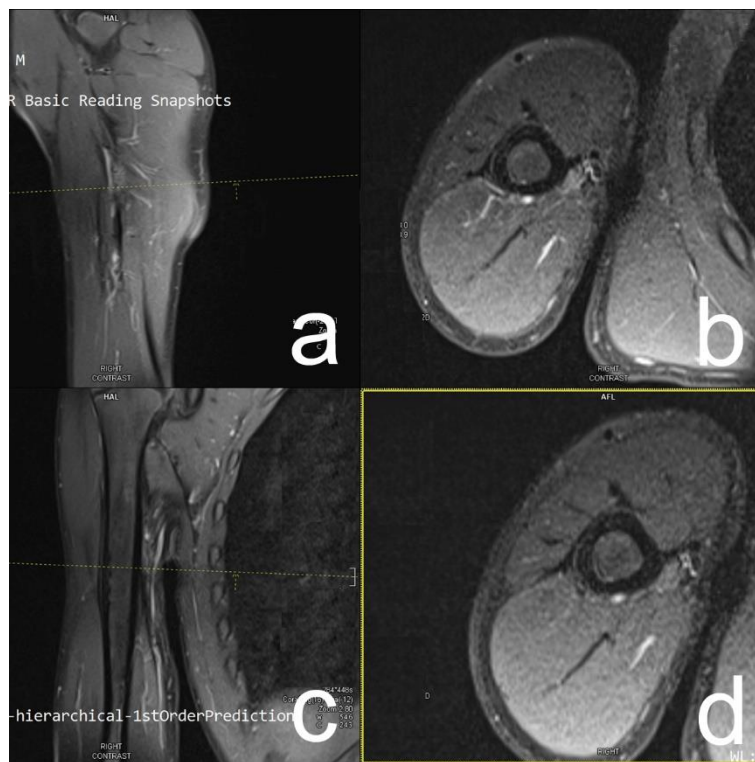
Postoperative MRI on the eight month after operation
